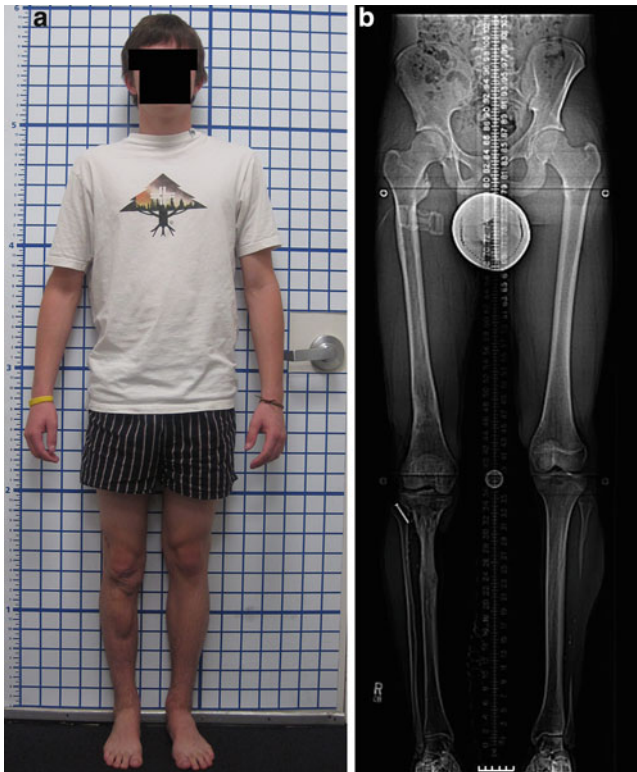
(a, b) Patient at age 17, *front view* and erect leg X-ray showing equal leg lengths and corrected deformity of both legs
